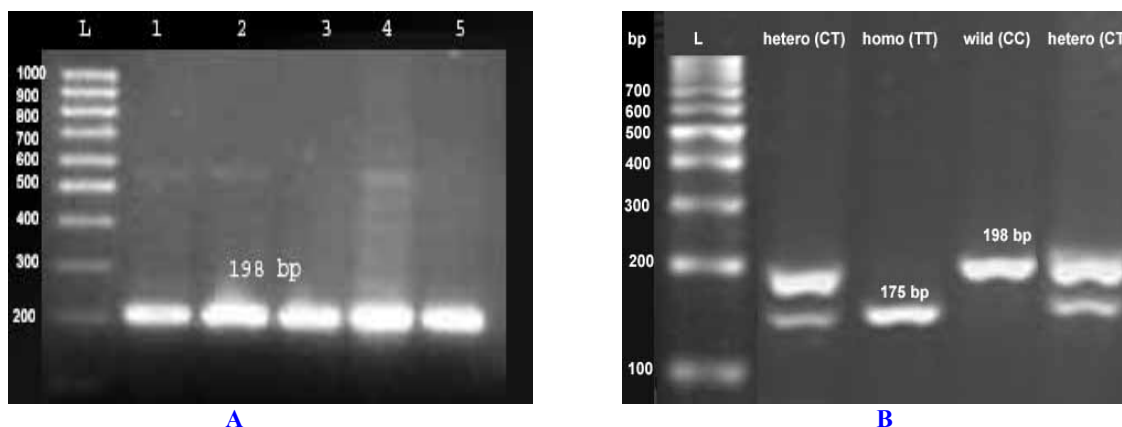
A. Represent the PCR product MTHFR C677T genotype bands in 198bp fragments. Polymorphism analysis of the methylenetetrahydrofolate reductase gene (MTHFR) amplicons by agarose gel electrophoresis after restriction endonuclease digestion (RFLP). CT genotype yields 198bp and 175bp TT genotype (175bp), and CC (198bp). L: Ladder molecular weight.
